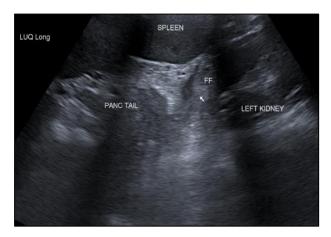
Longitudinal ultrasound of the left upper quadrant demonstrating a small amount of free fluid (arrow) adjacent to the pancreatic tail, consistent with acute pancreatitis.
